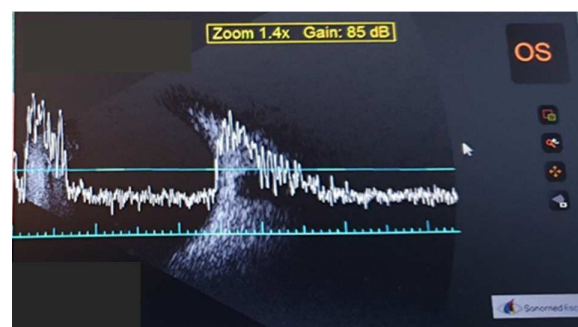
The B-scan ultrasonography of the left eye with hyperreflective areas on the optic disc corresponding with spikes on A-scan.
